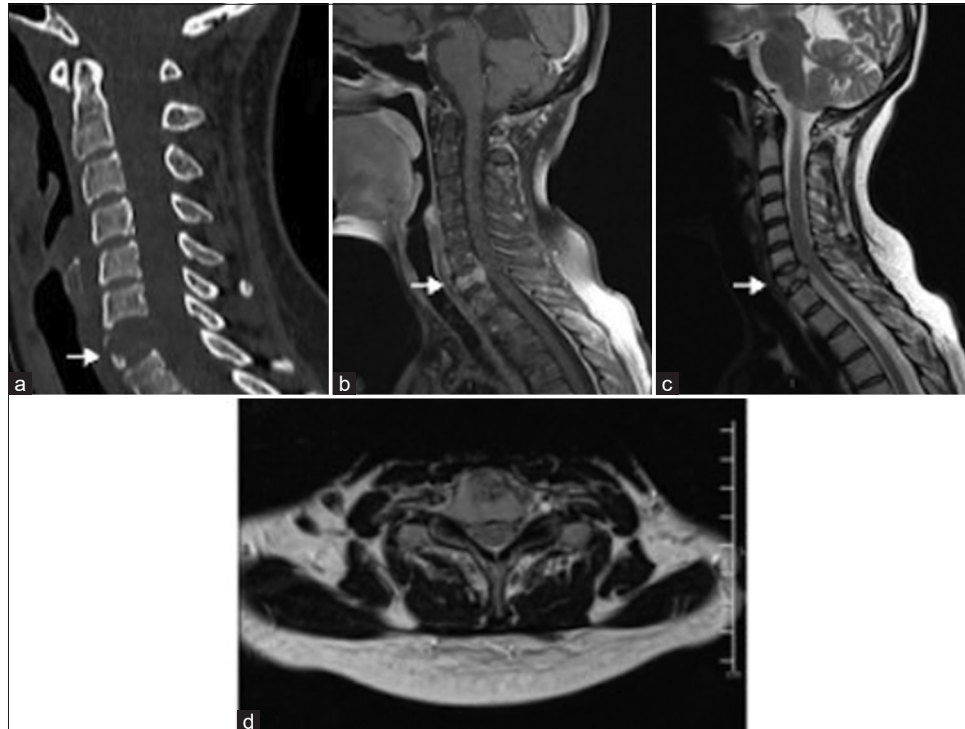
(a) Computed tomography sagittal view of the cervical spine showing a collapsed C7 vertebral body with retropulsion and expansile C7 vertebral body lesion, replacing most of the vertebral body. (b) T1 post-contrast and (c) T2-weighted sagittal and (d) Axial magnetic resonance imaging. Decreased vertebral height of C7 vertebra with mild retropulsion and intense post-gadolinium enhancement of the vertebral body and right pedicle.
